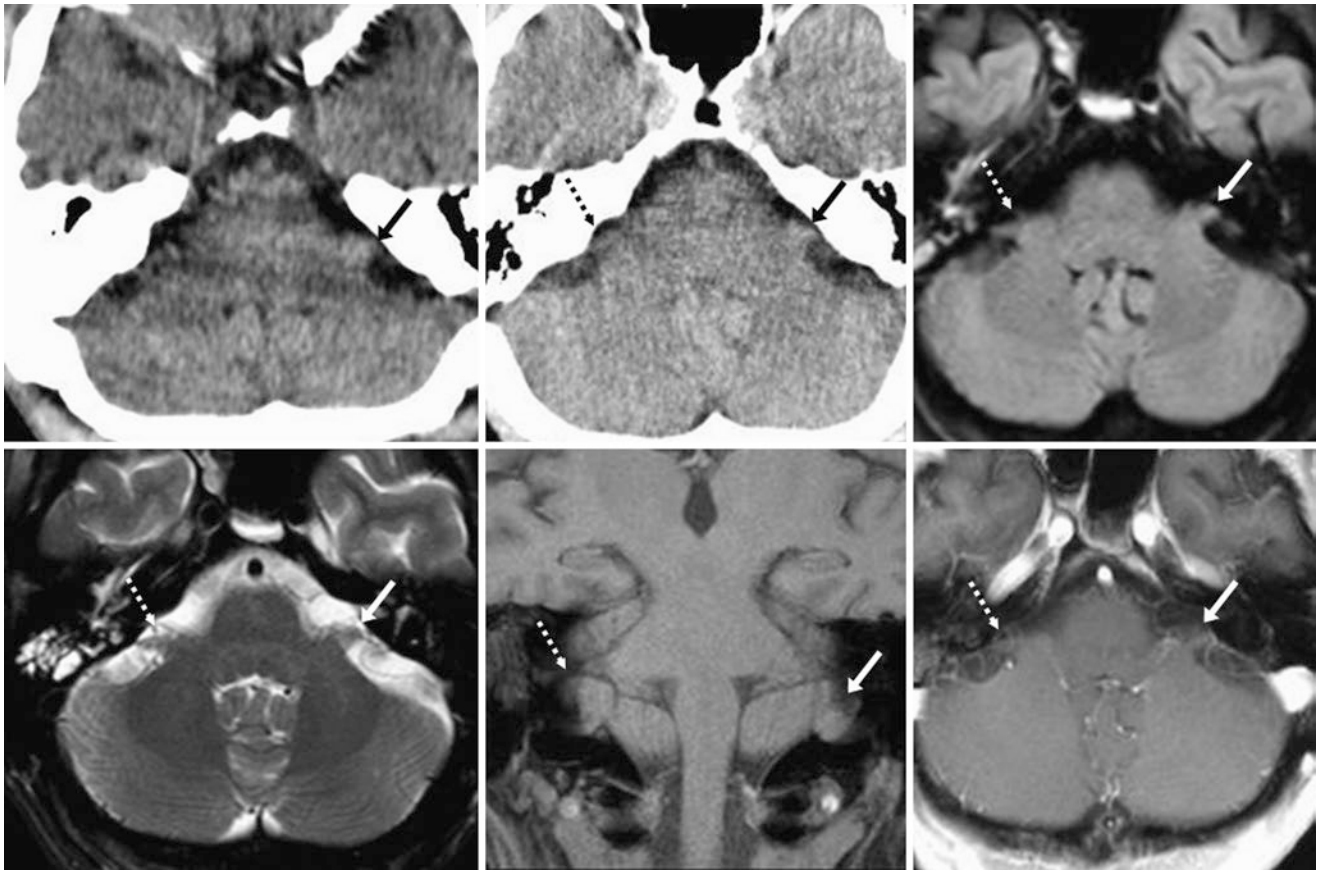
A 55-year-old patient with headaches and balance problems (negative study). On NECT (*top left*), there was a prominent hyperdensity within the left CPA (*arrows*), unchanged from 5 years previously (*top middle*). A 1.5 T MRI axial FLAIR (*top right*), T2WI (*bottom left*), coronal T1WI (*bottom middle*), and postcontrast T1WI (*bottom right*)
